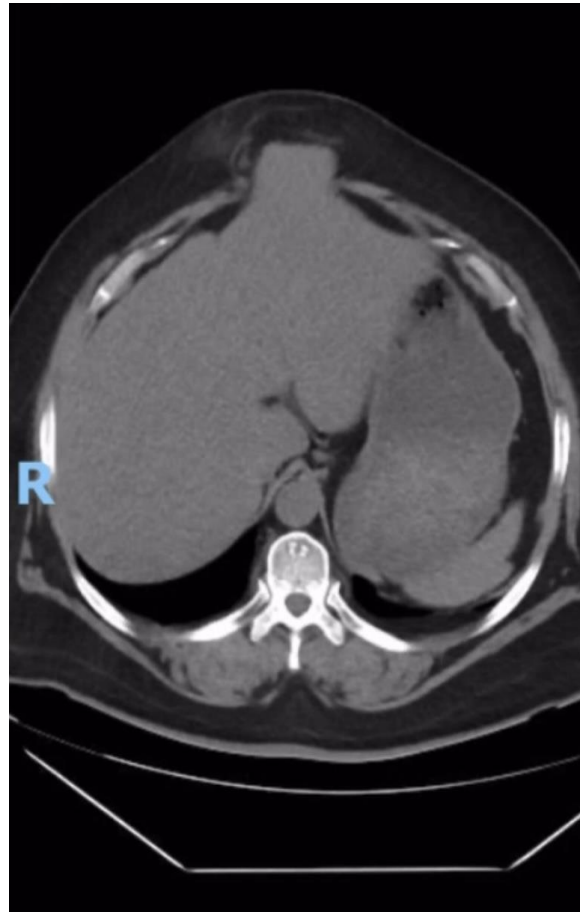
Abdominal CT scan, axial view showing herniation of the left hepatic lobe.
